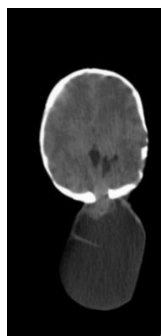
Axial CT parenchymal window-levelled image reveals a hypodense encephalocele sac containing brain tissue. Fronto-parietal bone scalloping is also visible
